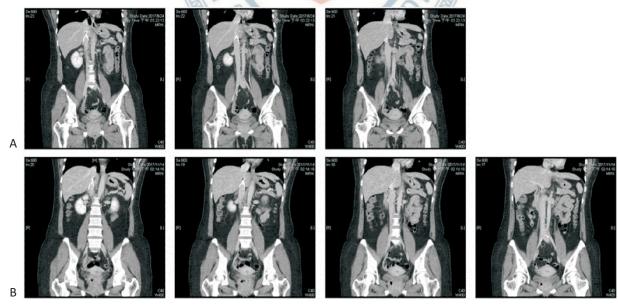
(A) No blood clot is observed in the computed tomography (CT) image 6 weeks later to the inferior vena cava (IVC) filter implantation. (B) The follow-up CT image 2 weeks after the IVC filter removal presents patent both IVC and right common iliac vein.
